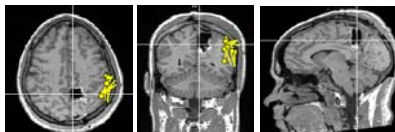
Preoperative multilobar MEG superimposed to the postoperative MRI; Excision superior parietal lobule, MEG focus not resected; Non seizure-free outcome.
